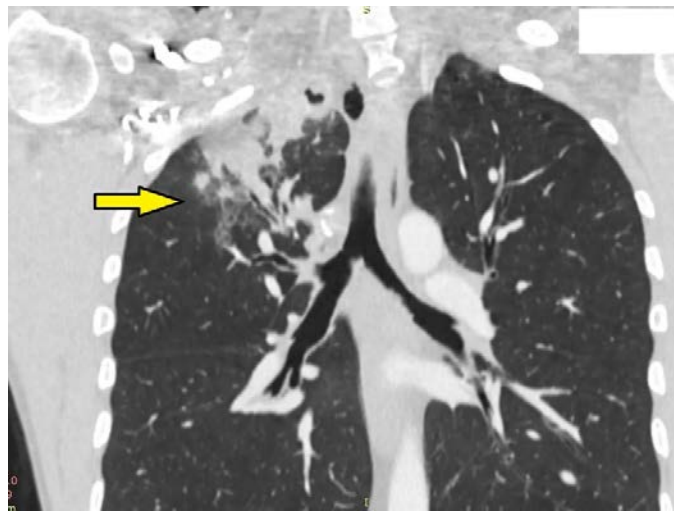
Chest multi-detector computed tomography: adjacent zones of patchy consolidation and pneumonitis.
